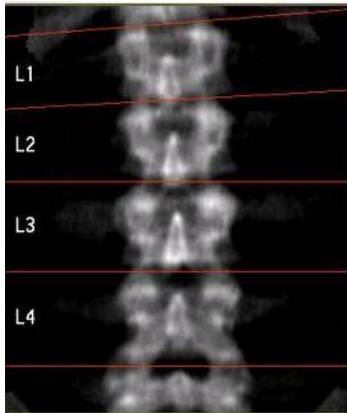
Dual Energy X-ray Absorptiometry (DEXA) scan of a human spine.
